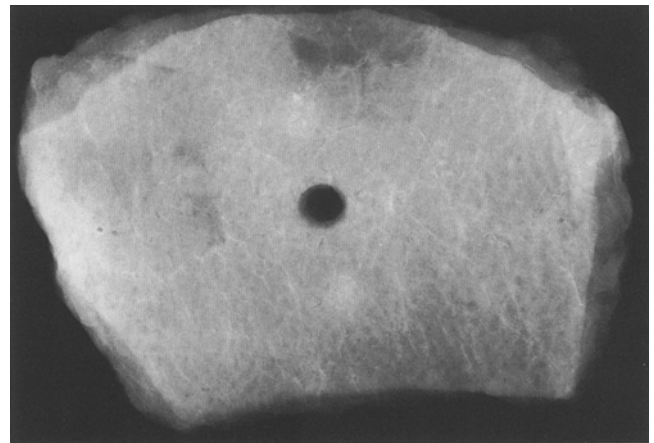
Injury caused by humane killer (low energy X-ray imaging). Typical smoke residues and 2 separate smoke rings in the area of the entry wound are clearly visible
